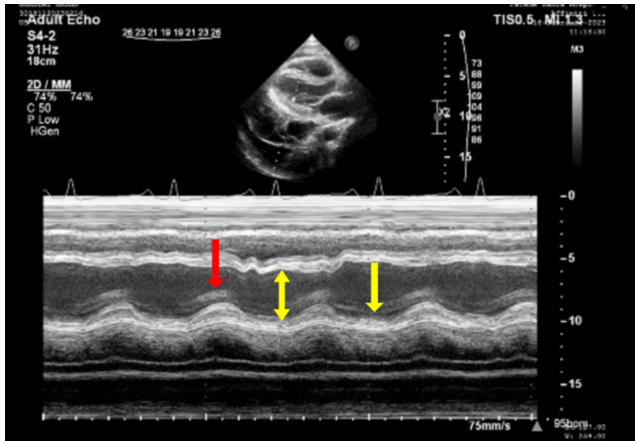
TTE imaging results: M-mode parasternal long axis shows septal bounce. The red arrow points towards expiration motion and the yellow arrows point towards inspiratory motions.
